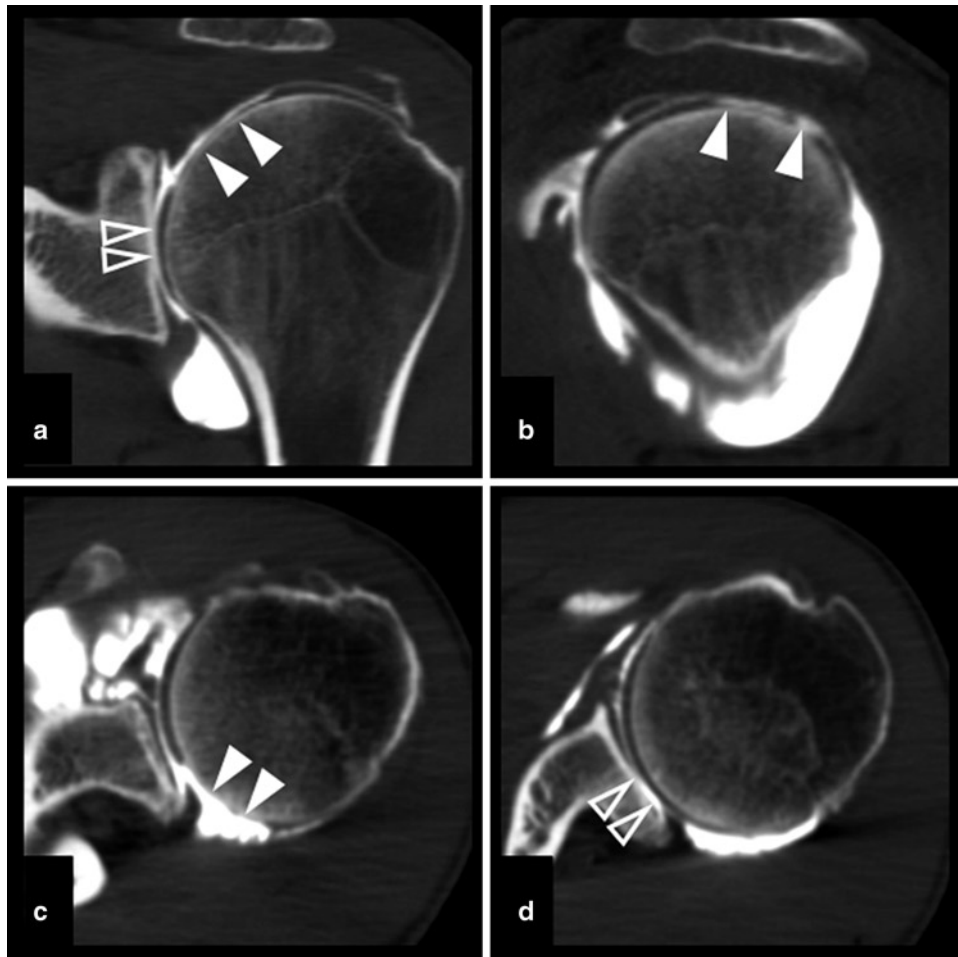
(a–d) Computed tomographic (CT) arthrography of the shoulder in a 40-year-old man. (a) Coronal, (b) sagittal, and (c, d) axial reformats show extensive grade 4 cartilage lesions of the posterior aspect of humeral head (*arrowheads*) and glenoid cavity (*open arrowheads*)
